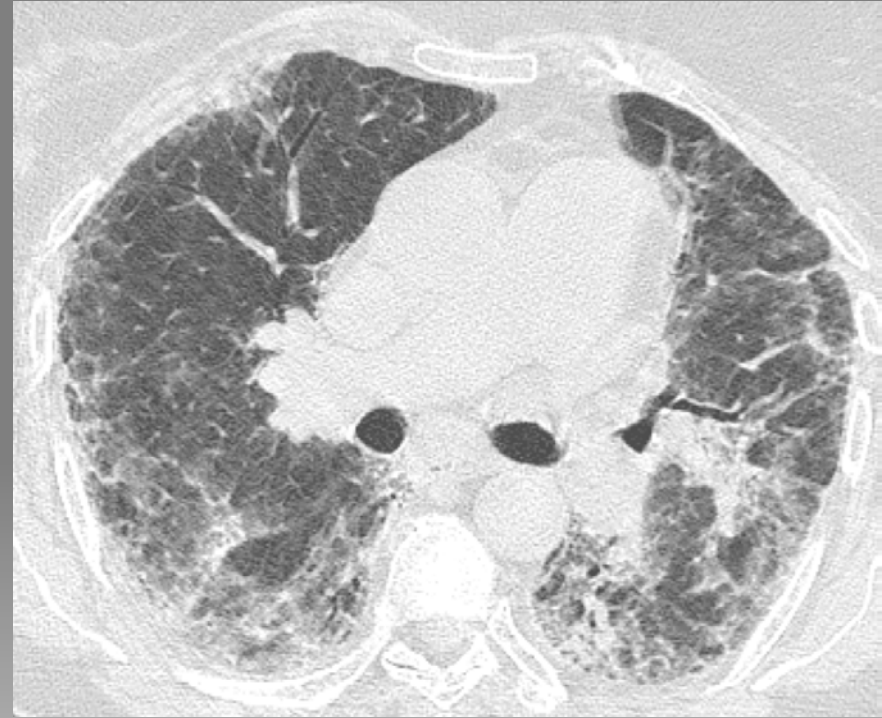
Image from Akira M et al. Computed tomography findings in acute exacerbation of IPF. AJRCCM 2008; 178(4):372-8.
